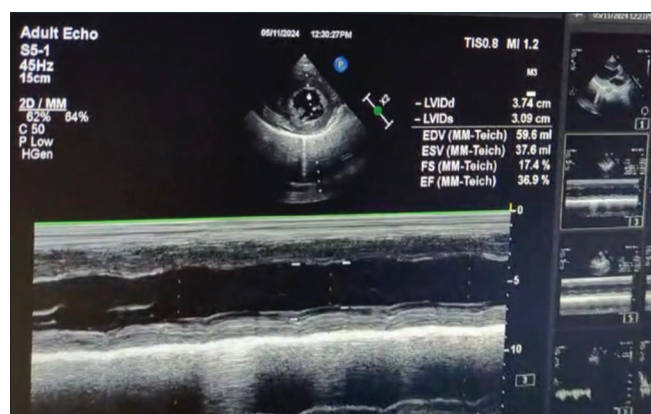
Echocardiogram showing reduced ejection fraction of 25%
